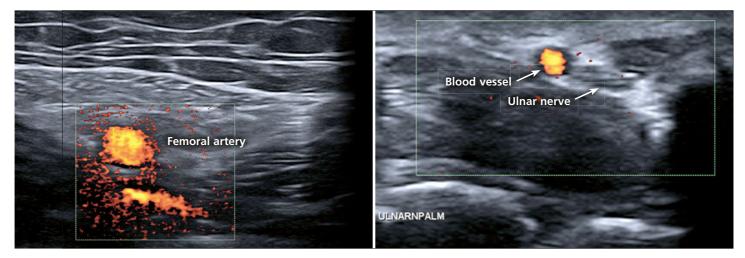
The color Doppler allows for faster identification and assists with avoiding vascular puncture.
